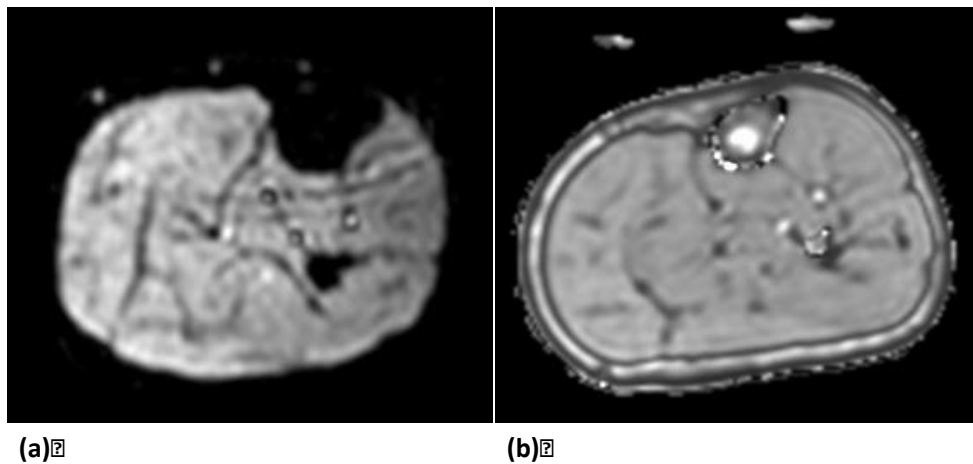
EPI (a) versus GRE (b) BOLD-MRI showing the higher spatial resolution achieved with GRE sequence showing axial image from the calf.
